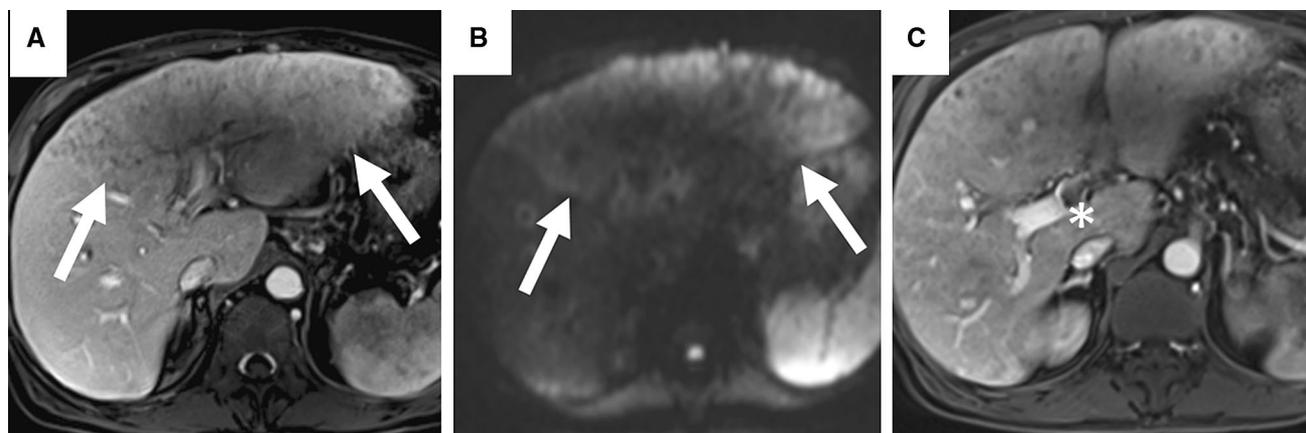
Geographic area of signal abnormality (arrows) involving segments 2, 3, and 4 which shows equivocal arterial enhancement (A). However, DWI shows restricted
